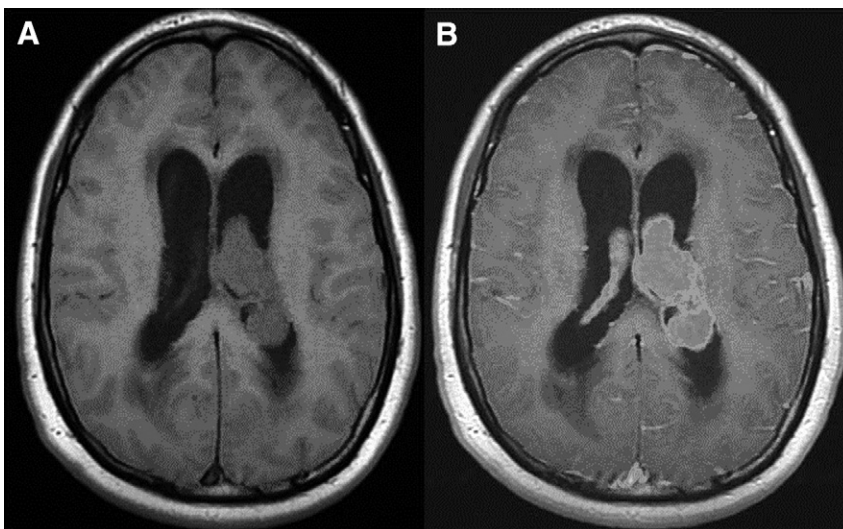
Pretreatment axial (A) noncontrast enhanced and (B) contrast enhanced magnetic resonance imaging of patient 1.
